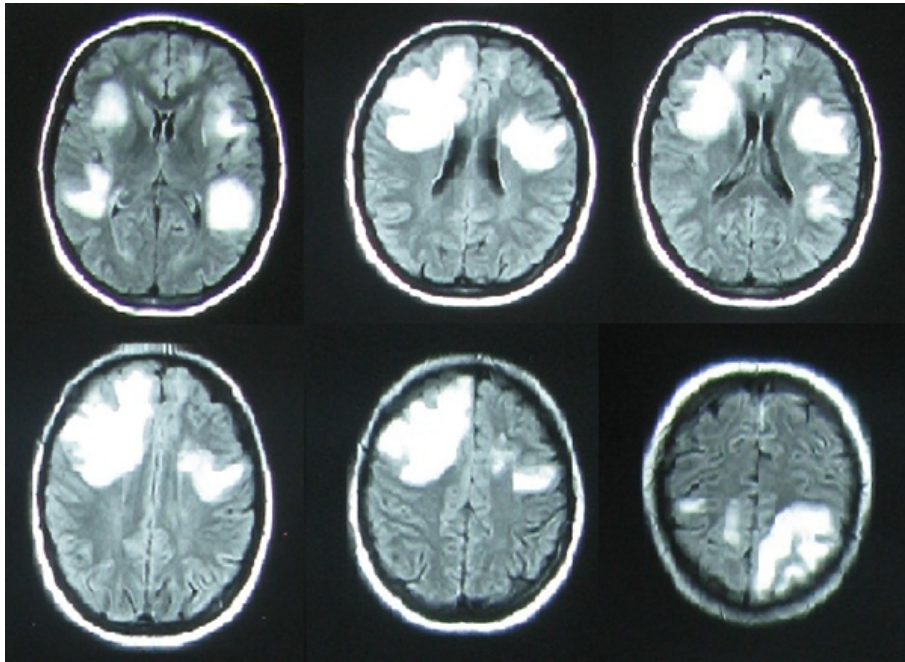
A 13-year-old female presents with Encephalopathy. Axial flare MRI shows tumefactive lesion in cortical and subcortical areas
